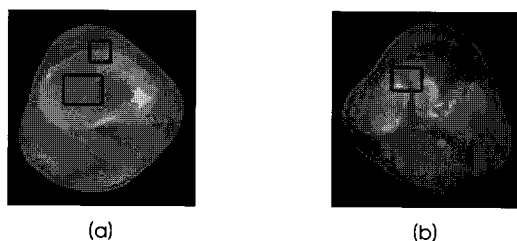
Typical CT images showing bones with challenging characteristics in segmentation such as (a) gaps and texture areas and (b) weak edges.
